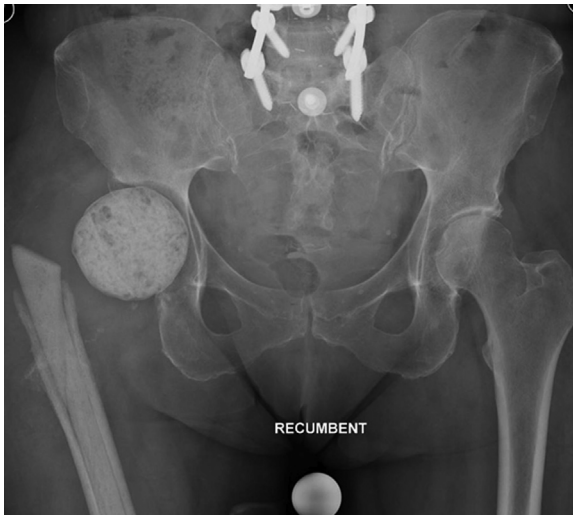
Preoperative anteroposterior radiograph with antibiotic-impregnated cement spacer in place demonstrating severe acetabular and femoral-sided bone loss.
